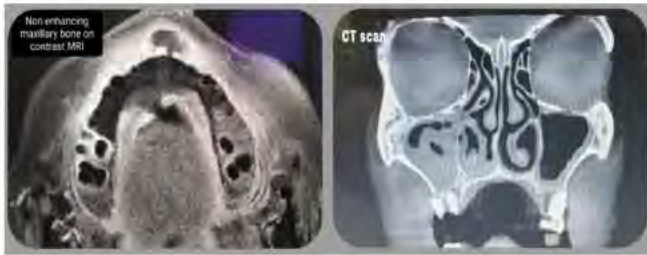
Contrast-Enhanced MRI
